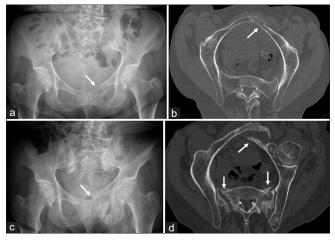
(a) A 83-year-old female suffers a slightly displaced leftsided pubic ramus fracture after a domestic fall. The AP pelvic radiograph shows a slightly shifted left pubic ramus fracture (arrow) but does not clearly show the posterior pelvis. (b) The oblique computed tomography (CT) reconstruction in the plane of the pelvic brim shows the slightly displaced pubic ramus fracture (arrow). There is no fracture in the posterior pelvis. (c) After 3 months of conservative treatment, the patient has continuing pain in the left groin and new pain in both buttocks. Mobility is severely restricted. The AP pelvis radiograph shows a more pronounced displacement of the left pubis ramus fracture (arrow). (d) The oblique CT- reconstruction of the pelvis in the plane of the pelvic brim shows the severe displacement of the pubic ramus fracture. In addition, complete fractures of both sacral ala are visible (arrows).
